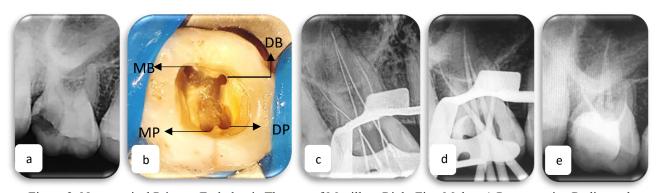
Non-surgical Primary Endodontic Therapy of Maxillary Right First Molar. a) Pre-operative Radiograph; b) Access Cavity Preparation; c) Working Length Radiograph; d) Master Cone Radiograph; e) Post-operative Radiograph.
